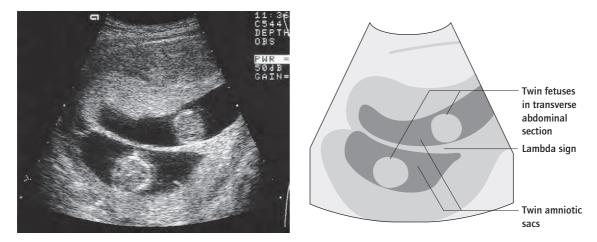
Ultrasound of DC twins in early pregnancy showing the lambda sign.
